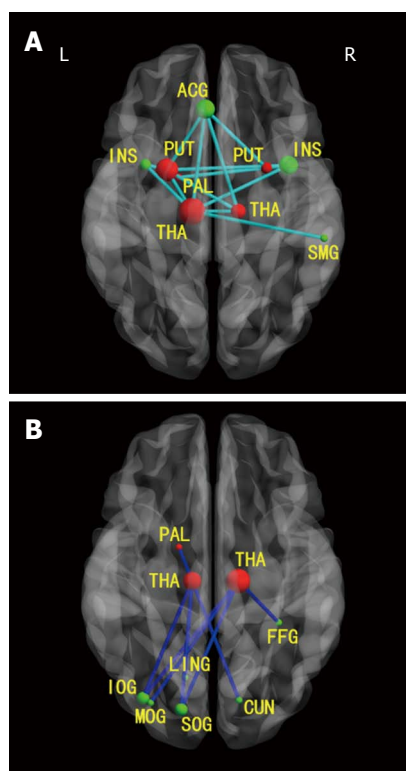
Axial magnetic resonance images show functional connectivities in patients with minimal hepatic encephalopathy between cortical and subcortical regions. A: Decreased positive functional connectivities between cortical and subcortical regions; B: Decreased negative functional connectivities between cortical and subcortical regions. Green nodes: Cortical ROIs; red nodes: Subcortical ROIs; light blue lines: Decreased positive connectivities in patients with minimal HE; dark blue lines: Decreased negative connectivities in patients with minimal HE. R: Right; L: Left; ACG: Anterior cingulum gyrus; SMG: Supramarginal gyrus; PUT: Putamen; PAL: Pallidum; THA: Thalamus; CUN: Cuneus; LING: Lingual gyrus; SOG: Superior occipital gyrus; MOG: Middle occipital gyrus; IOG: Inferior occipital gyrus; FFG: Fusiform gyrus; INS: Insula. From reference [54] (with permission).
